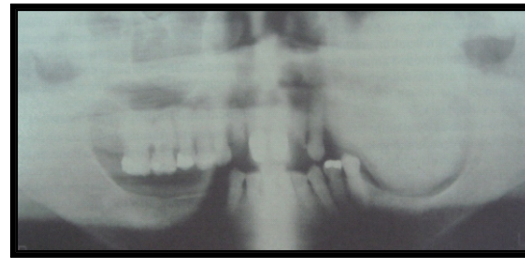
Panoramic radiograph showing "ground-glass" appearance
